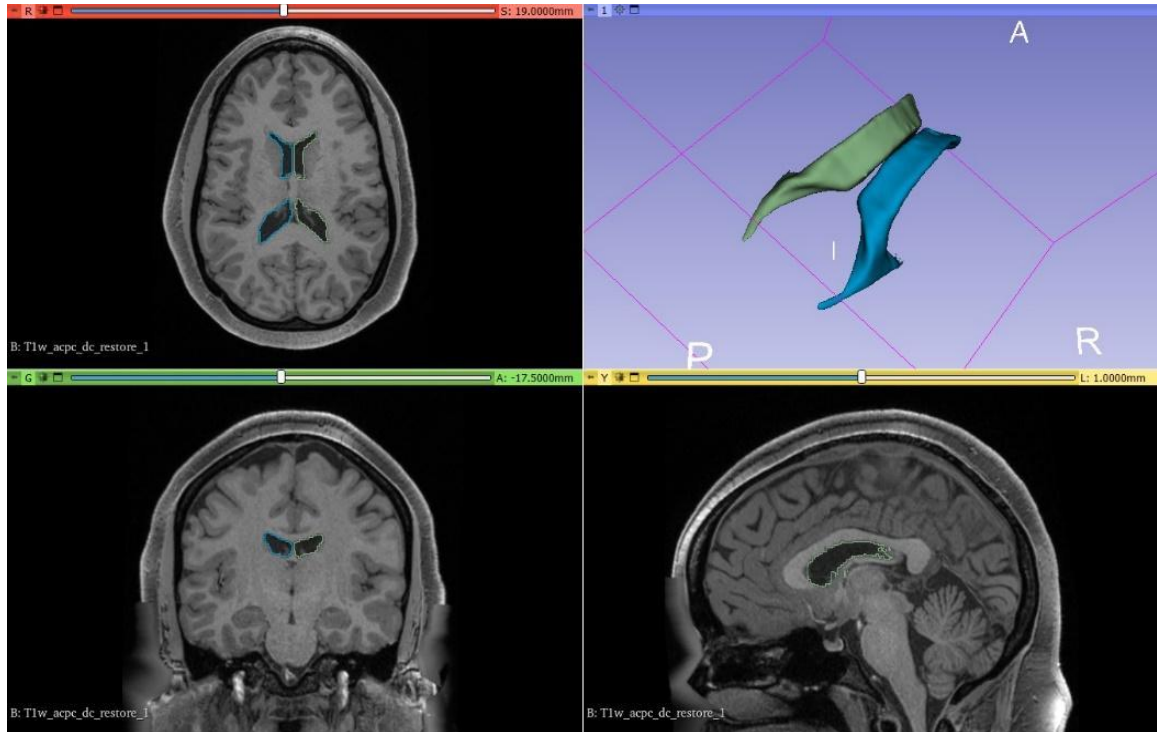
Visualization of MRI dataset in 3D Slicer. Three different views of the same volume are shown: axial (red window, upper left), sagittal (yellow window, lower right), coronal (green window, lower level), and a 3D visualization window of any segmentation. For this study, the green (Coronal) view was primarily utilized for visualization and measurement.
